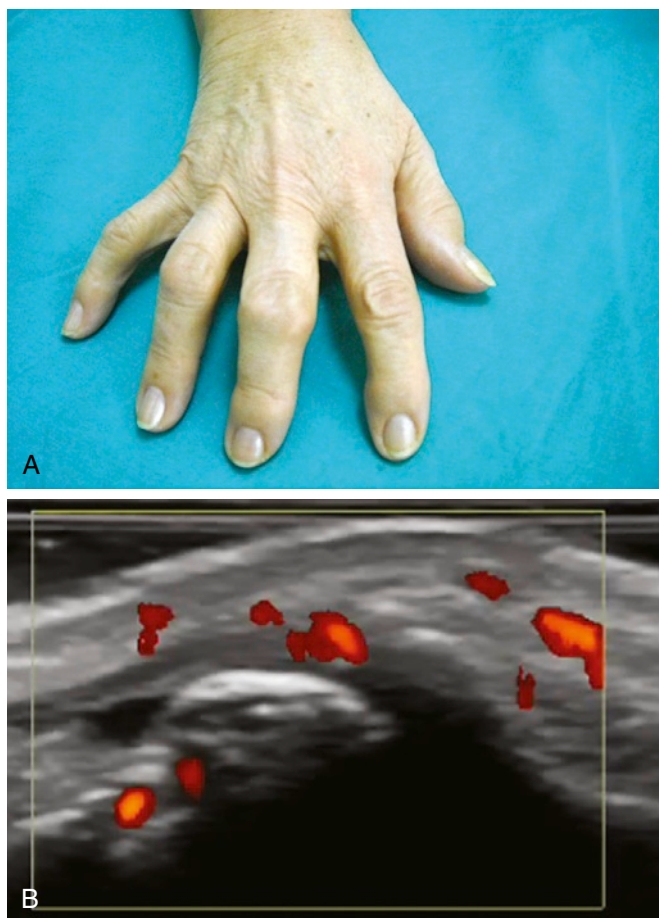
A, Ultrasound is used to assess the hands of a patient with osteoarthritis and inflammation of Bouchard's nodes. B, Power Doppler shows local inflammation involving the proximal interphalangeal joints due to synovial hyperemic phenomena.
